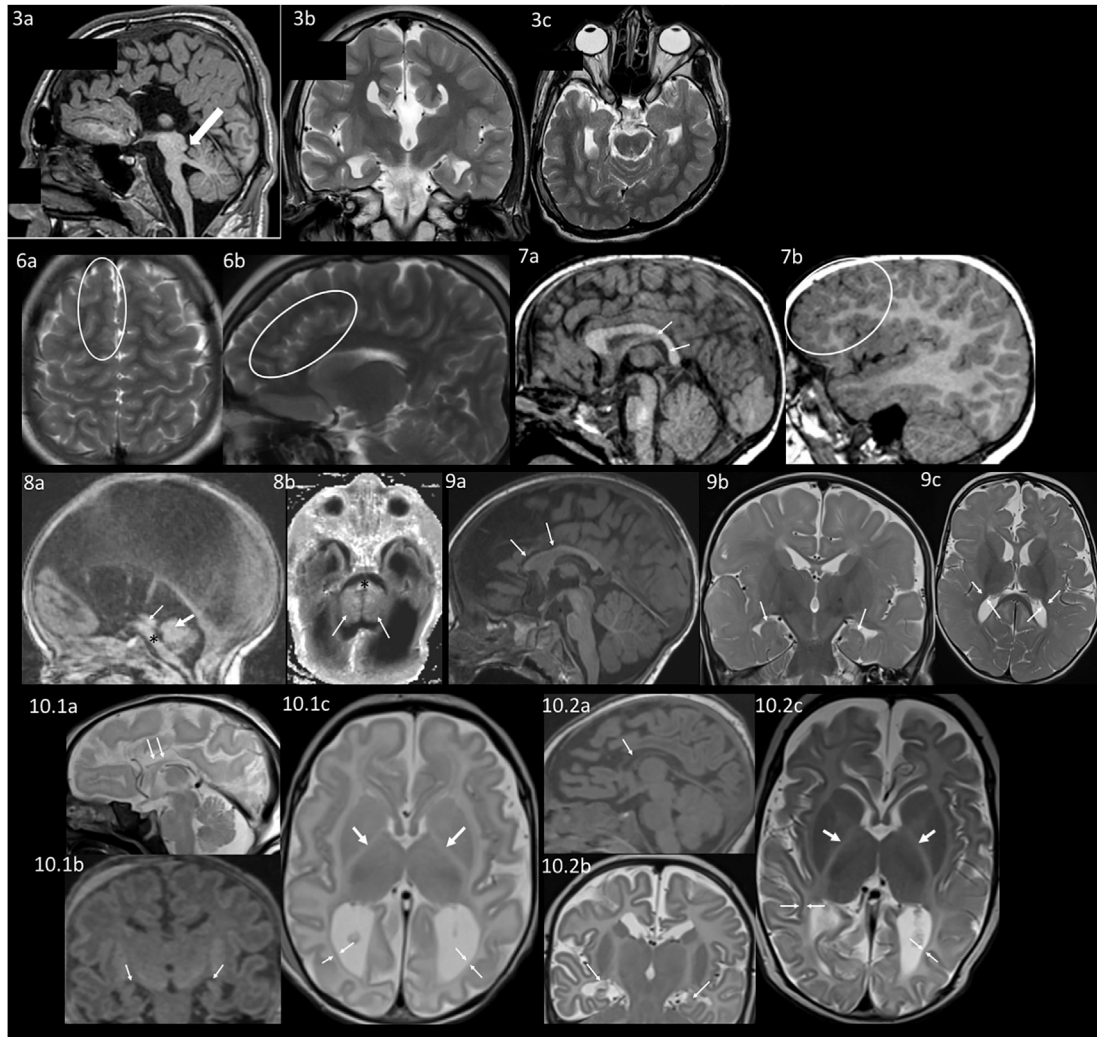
Neuroanatomical differences appreciated on brain MRI
